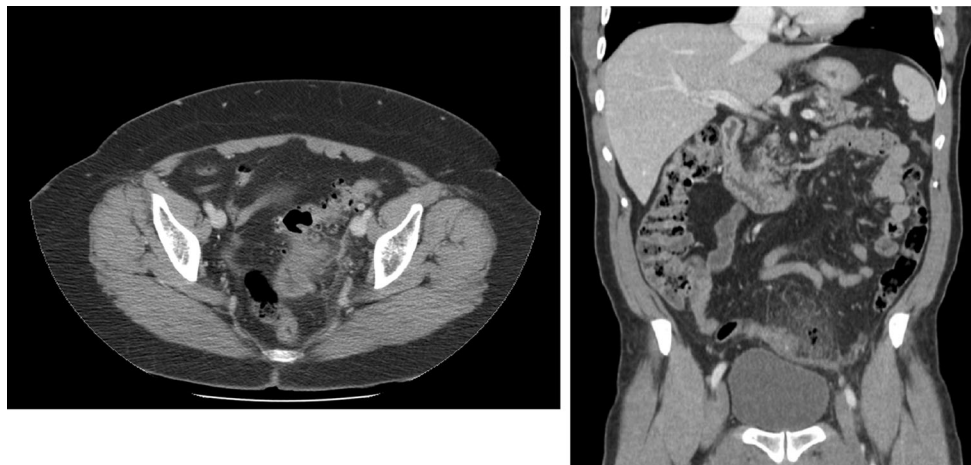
Left* abdominal computed tomography (CT) cut showing mNeff 0 acute diverticulitis (wall thickening and increased pericolic fat density); *right* abdominal CT cut showing mNeff Ia acute diverticulitis (locally increased pericolic fat density and air bubbles)
